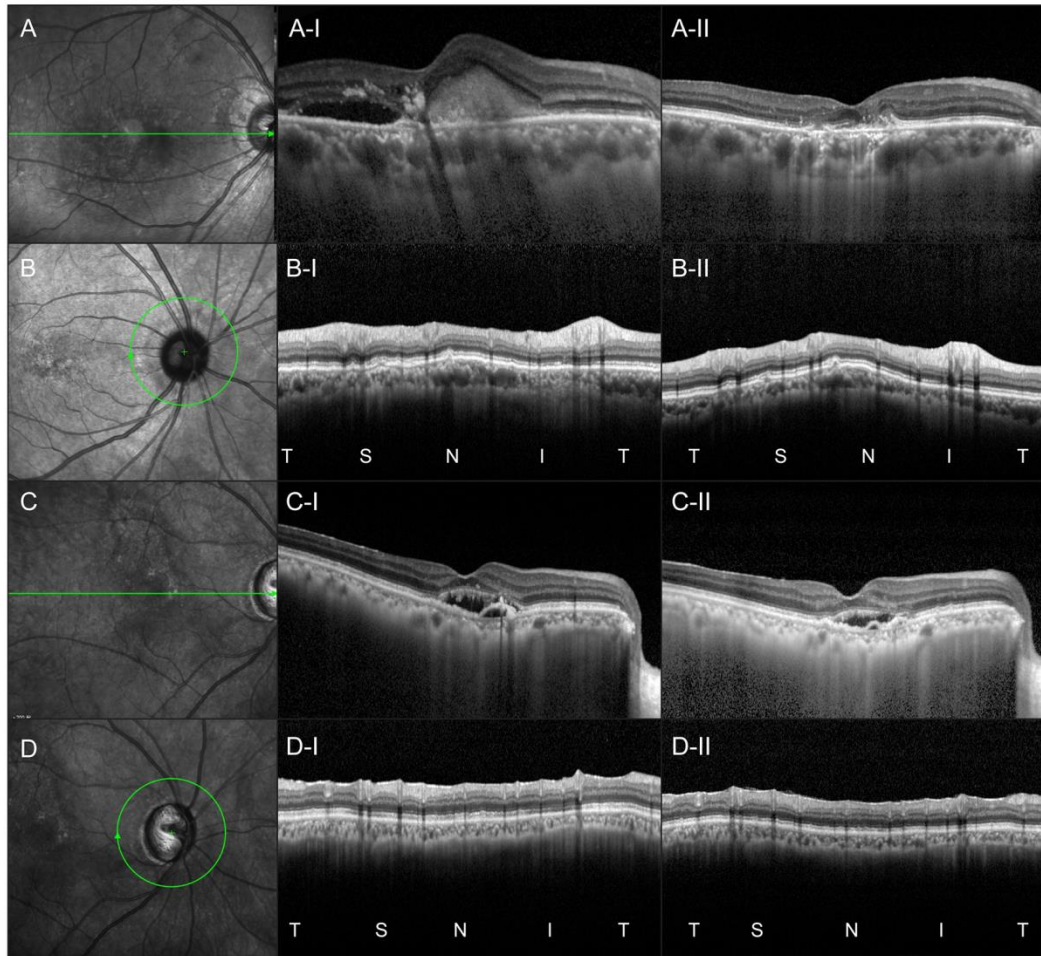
Representative case of peripapillary choroidal thickness (PCT) change after anti vascular endothelial growth factor (VEGF) in polypoidal choroidal vasculopathy (PCV) and exudative age related macular degeneration (AMD). (A, B) Seventy years old female with PCV (A-I, II) Subfoveal choroidal thickness (CT) decreased from 407  $\mu\text{m}$  to 303  $\mu\text{m}$ . (B-I, II) Mean PCT was 198  $\mu\text{m}$  and decrease to 150  $\mu\text{m}$  after anti-VEGF (25 %). (C, D) Seventy seven years old female with exudative AMD (C-I, II) Subfoveal CT decreased from 190  $\mu\text{m}$  to 175  $\mu\text{m}$  (D-I, II) Mean PCT was 119  $\mu\text{m}$  and 114  $\mu\text{m}$  before and after anti-VEGF, respectively.
